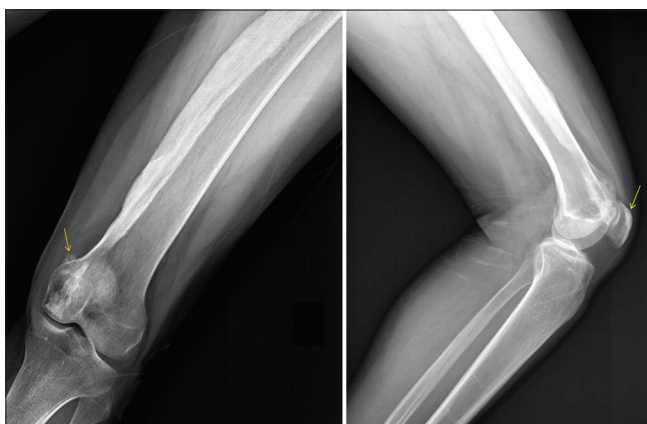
AP and lateral radiographs of left knee and femur show flowing “candle wax” like ossification along medial cortex of femur. A small focus of soft tissue calcification is seen on the AP radiograph medially adjacent to the patella (orange arrow). The lateral radiograph shows few foci of sclerosis within the patella (yellow arrow)
